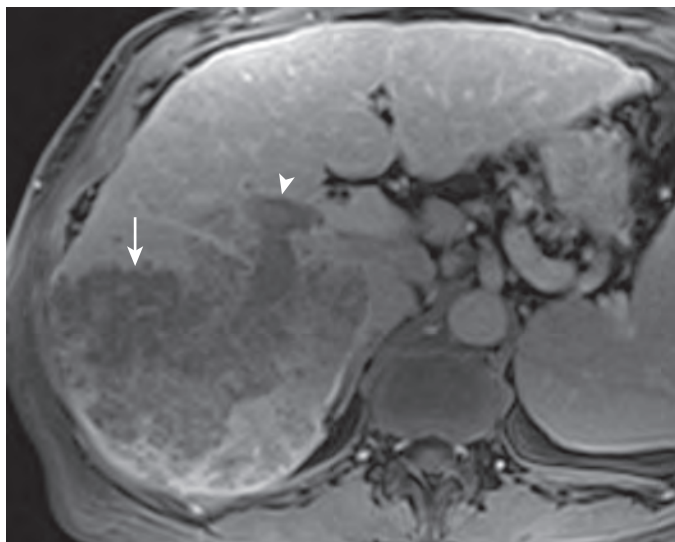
Infiltrating HCC with portal venous invasion. Venous phase MR image shows a large infiltrating HCC (arrow) with invasion of the portal vein (arrowhead). The large size and portal venous invasion exclude this patient from liver transplantation (Milan criteria).
